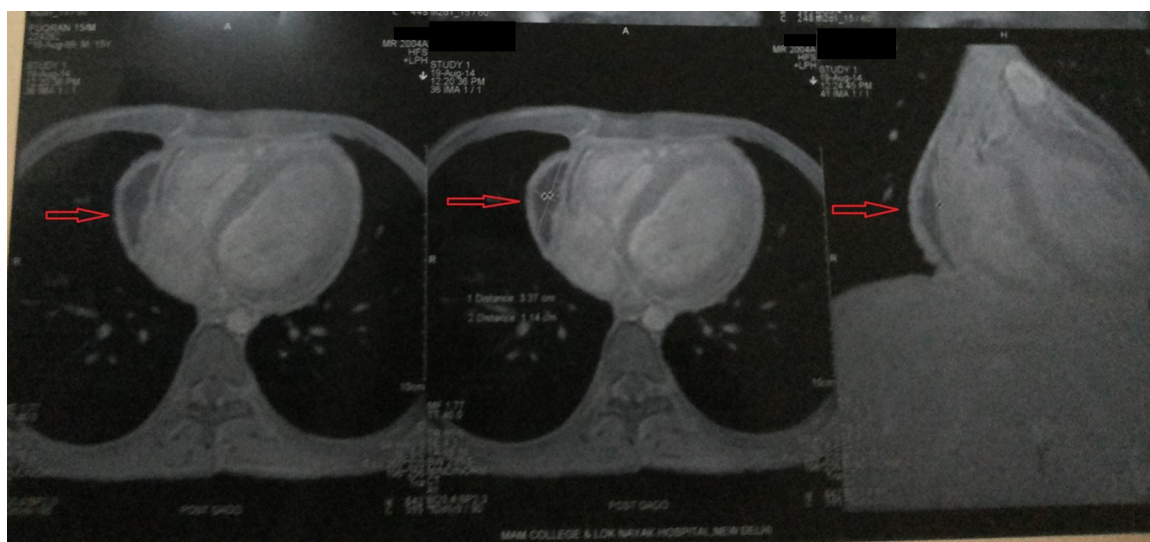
Cardiac MRI showing pericardial thickening with a loculated thick walled peripherally enhancing pericardial collection on right side (arrow) along the right atrium and right ventricle chambers.
